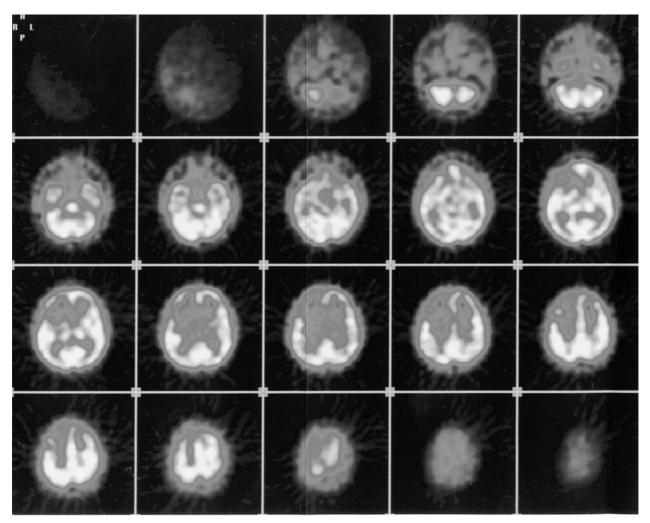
A brain SPECT study- in axial sections, the frontal part of the brain revealed severe perfusion deficits, which appears as a darker, redder colour more prominent on the right side, case 2.
